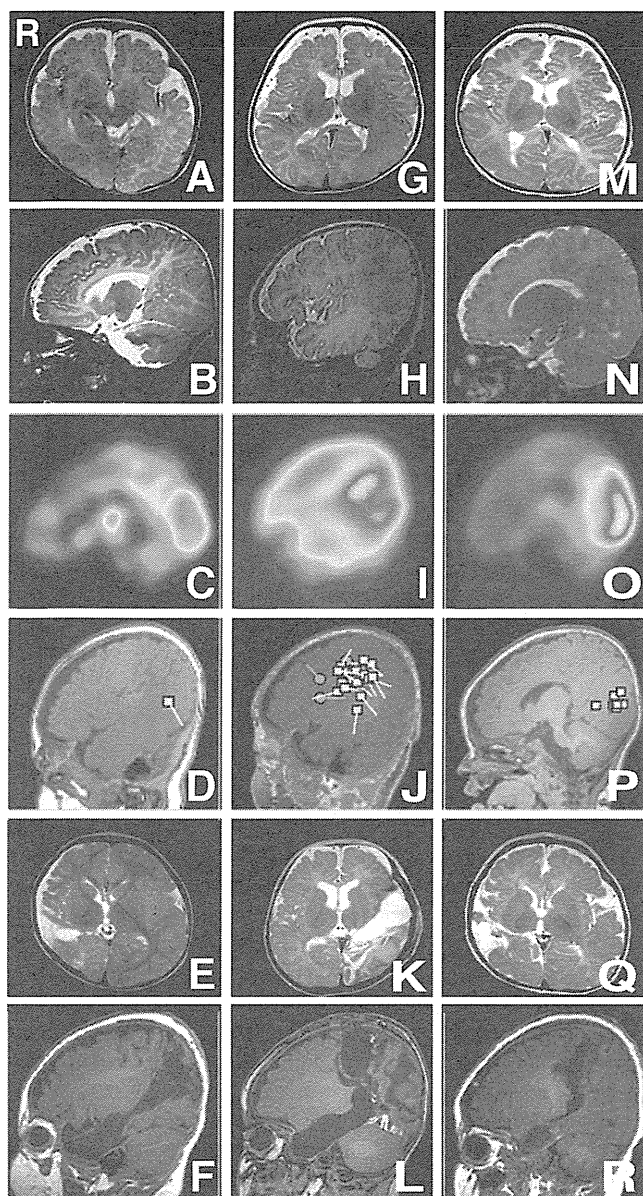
Neuroimages of Case 1 (A–F), Case 2 (G–L), and Case 3 (M–R). A, B, G, H, M, N: Magnetic resonance (MR) images demonstrating temporoparietooccipital cortical dysplasias. C, I, O: Ictal single photon emission computed tomography scans. D, J, P: Magnetoencephalography with superimposition onto sagittal MR images. E, F, K, L, Q, R: Postoperative axial and sagittal MR images showing the site of posterior disconnections.
